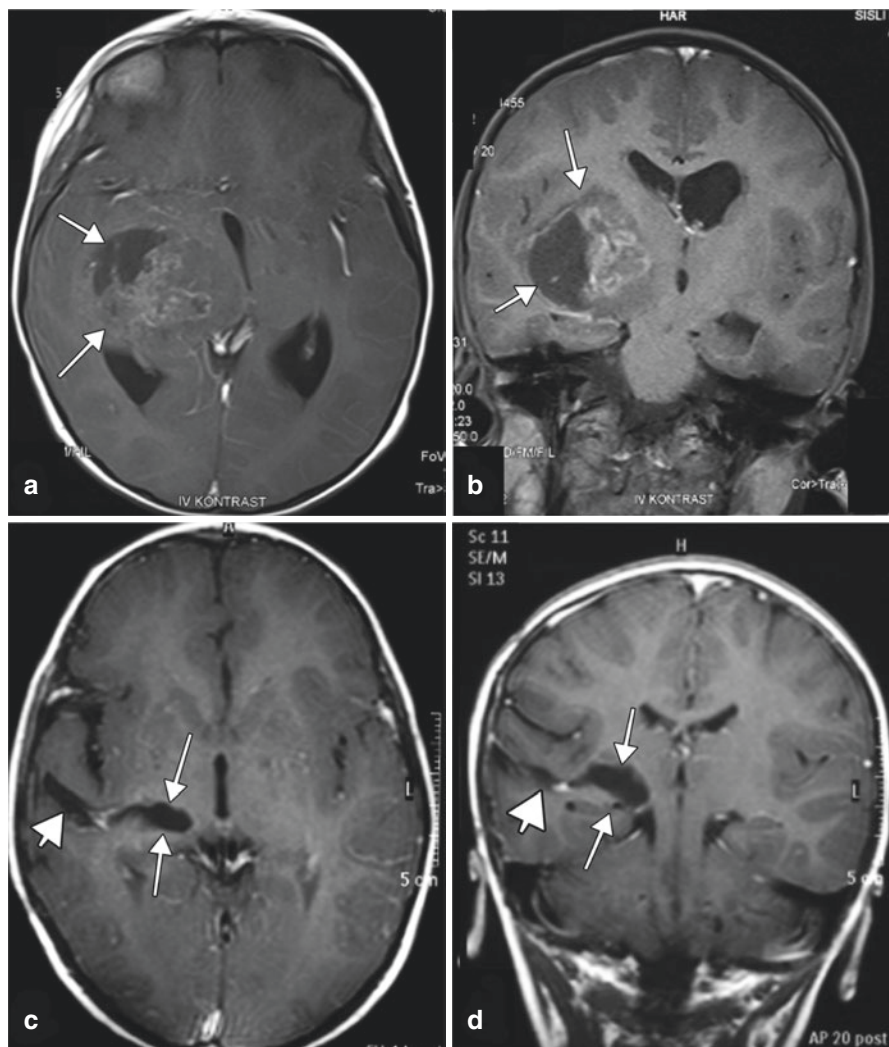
5 years old patient presented with mild hemiparesis. (a) T2-weighted MR imaging demonstrated cystic large lesion in the right thalamic region. (b) Early postoperative CT demonstrates complete removed using transcortical-temporal approach
